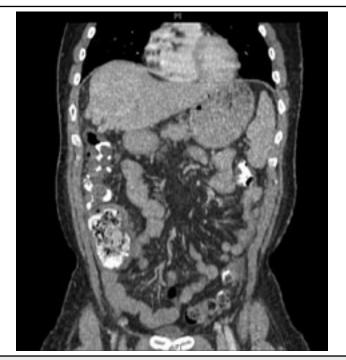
Sagital reconstruction of a CT scan with intravenous and oral contrast taken 5 hours after the previous CT scan, demonstrating the absence of intussusception and a thickened bowel with thumbprinting.
